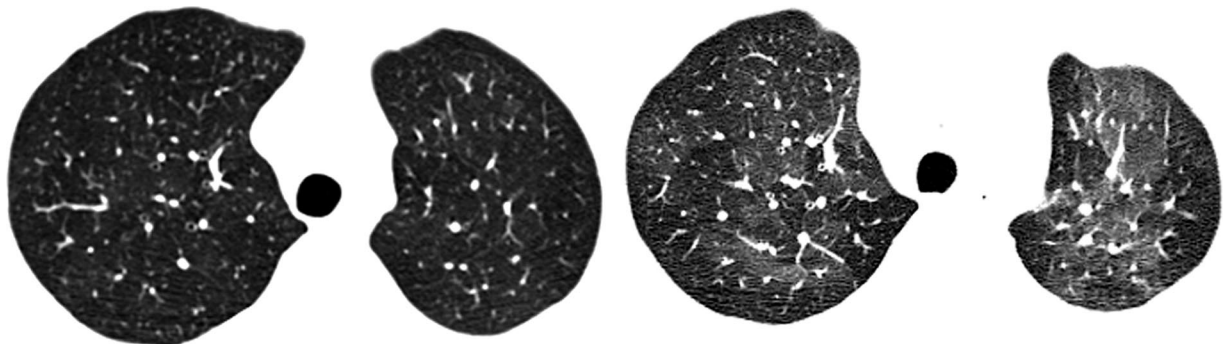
Constrictive bronchiolitis in the late posttransplantation period. CT scans obtained during inspiration (a) and expiration (b) show hypoattenuating secondary lobules during expiration, which represent airtrapping from obstructed bronchioles.
